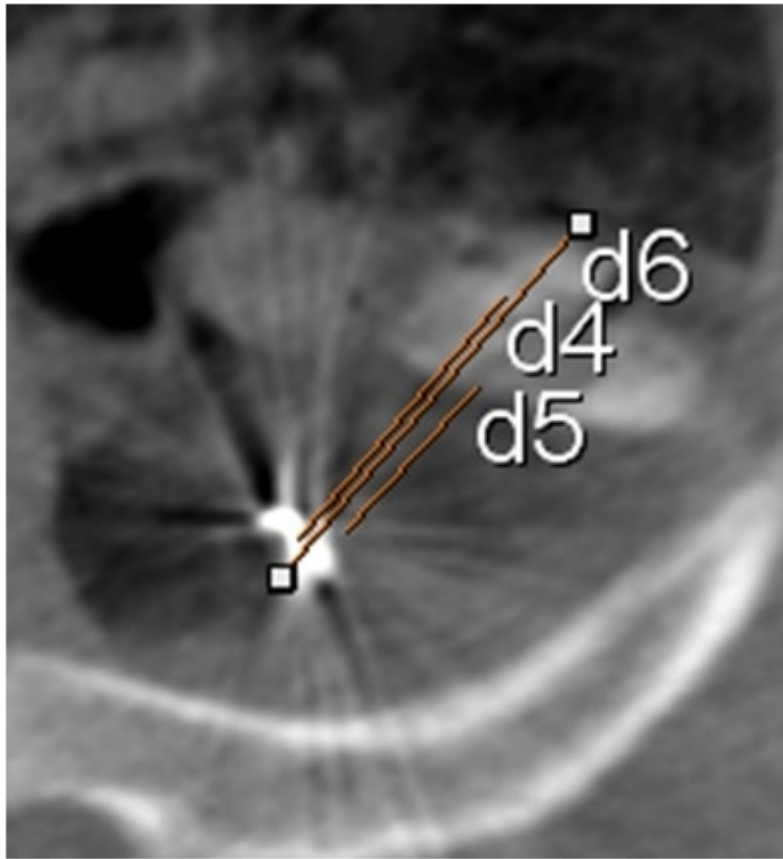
The Euclidean distance between the marking coil and the deployed tumour model was manually measured using the PACS ruler tool from 3D x-ray. The resultant images facilitated the measurement of centre-to-centre (labelled $d4$ in this image), closest (labelled $d5$) and further ($d6$) distances between the deployed marker coil and the tumour model. This procedure was repeated for each of the eight tumour models described in Table 1.
